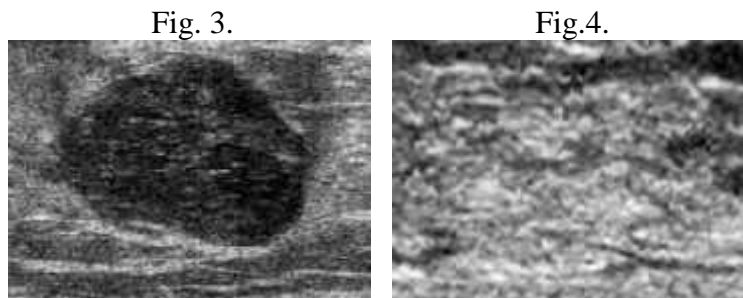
A breast mass detected by ultrasound examination. Fig.4. A suspicion mass assessed by ultrasound missed by mammography but detected by MRI
